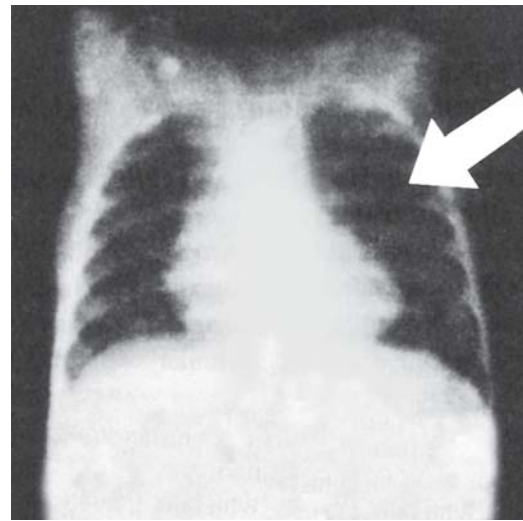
Chest X-ray in Fallot's tetralogy. Note the boot-shaped heart and oligemic lung fields
